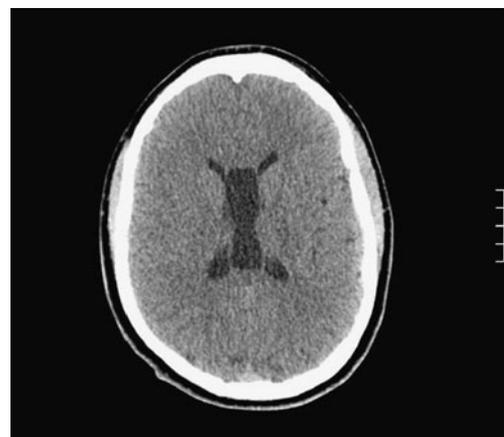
Axial MRI noting a cavum septum pellucidum
